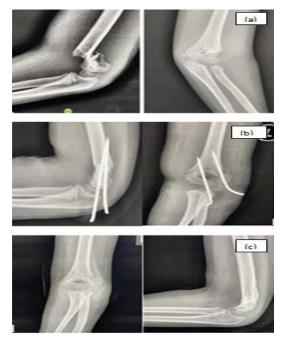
(a): Gartland Type III Supracondylar fracture Antero-posterior and Lateral views; (b): lateral pinning technique; (c): post-operative follow up radiograph at 12 weeks
